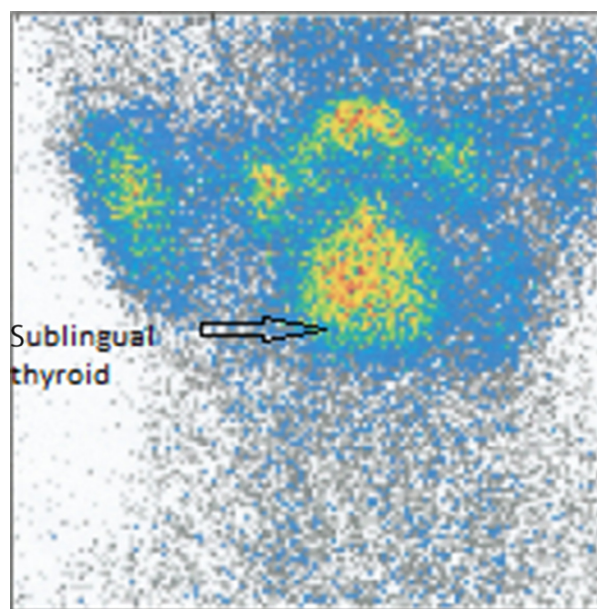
Thyroid scintigraphy acquired by a static mode 20 min after intravenous injection of ^{99m}Tc pertechnetate: high sublingual uptake.
